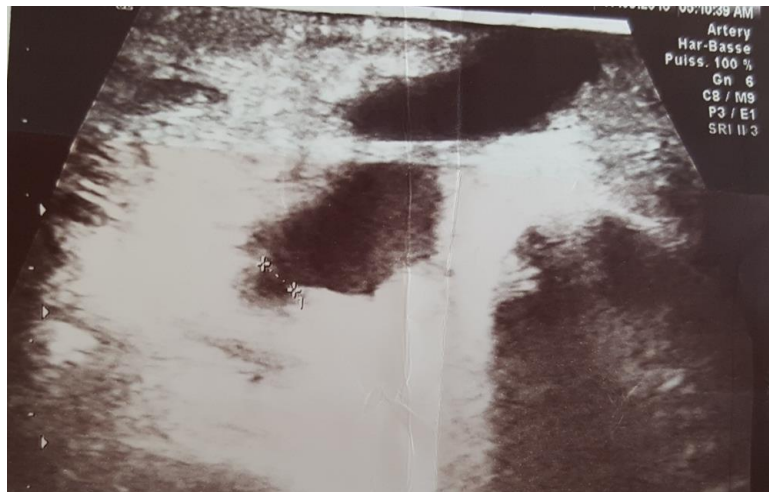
Sonographic image of the pseudoaneurysm
